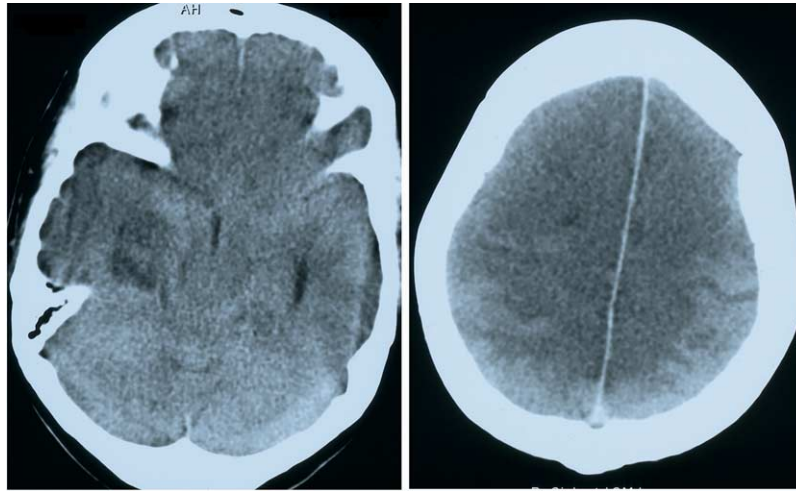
CT scan of a severely head-injured patient with diffuse brain swelling obtained 70 h following TBI. The lateral ventricles are narrow, the basal cisterns are compressed (left), gyri and sulci are no longer discernible (right).
